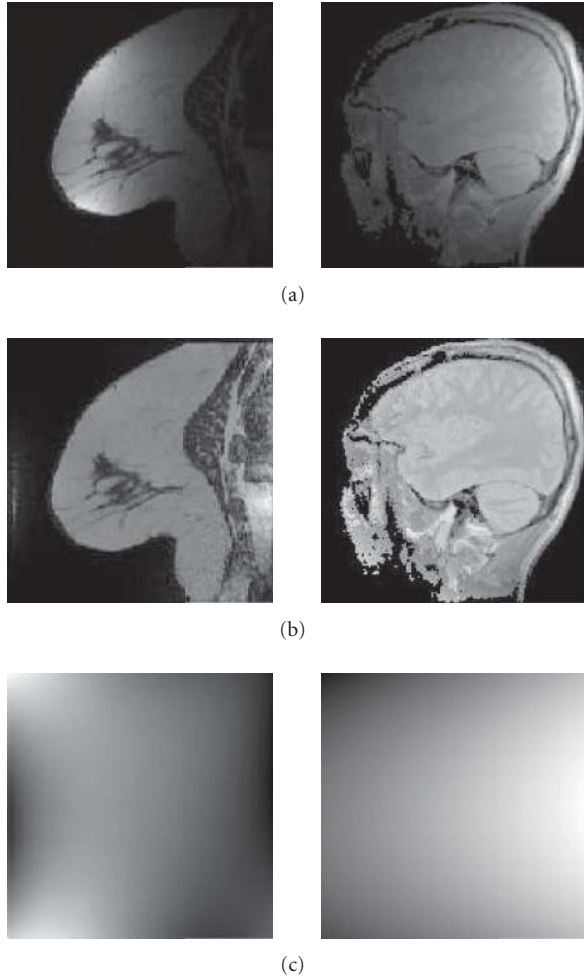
Sample MR images with severe intensity inhomogeneity: original images (a), corrected images (b), and estimated inhomogeneity maps (c).
